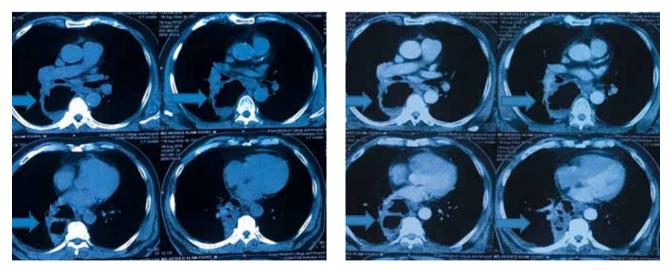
Pre- and post-contrast axial CT scan showing mild enhancing irregular thick-walled cavitary lesion at right lung field
